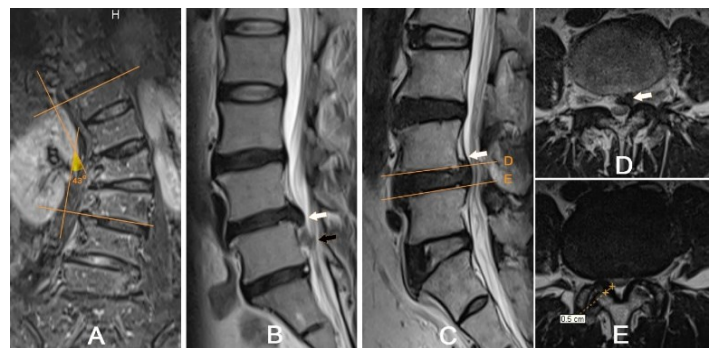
MR images of the lumbar spine demonstrate some causes of lumbar spinal stenosis. (a) - The coronal STIR-image in a 63-year-old female show scoliosis measured by Cobb method, Cobb = 43 degrees. (b) - Sagittal T2-weighted MR images of the lumbar spine in a 34-year-old female patient. A disk extrusion with an inferior migration of the intervertebral disk beyond the confines of the superior endplate of L5 (white arrow). A disk fragment (sequestered disk fragment) is also seen as inferior to the disk extrusion (black arrow). (c, d & e) - Sagittal T2-weighted MR images and axial T2-weighted MR image corresponding in the same patient as a 64-year-old man. Disk extrusion originating from the L4-L5 level and extending superiorly to be positioned in an infrapedicular location (white arrow in c & d), and accompanied by ligamentum flavum thickening causing severe spinal canal stenosis (e).
